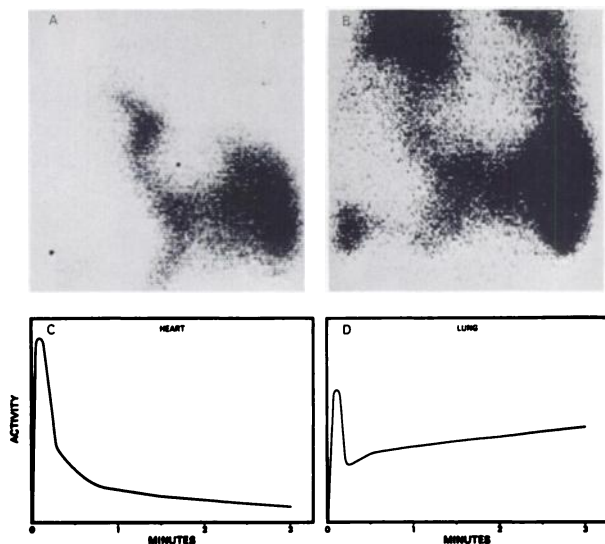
shows the anterior chest scintigram and the subtracted curve of nonblood pool lung activity in the patient with biopsy-proven malignant lymphoma\*. The scintigram shows lung uptake and the nonblood-pool lung activity curve is typical of reticuloendothelial extraction.
